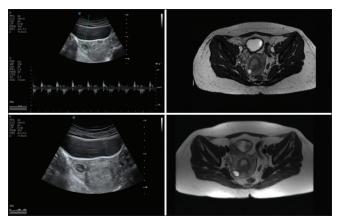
Transvaginal sonography and magnetic resonance images of interstitial pregnancy
